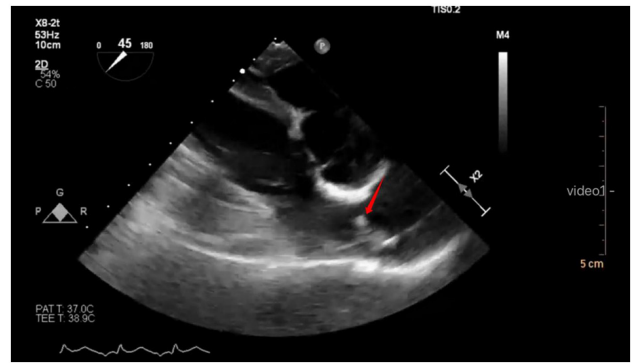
Transesophageal echocardiography image obtained by the authors from a 59-year-old female patient undergoing lung transplantation for interstitial lung disease. The image of a right ventricular inflow and outflow tract view, showing a floating thrombus near the pulmonary valve in the right ventricular outflow tract, marked by the red arrow.
